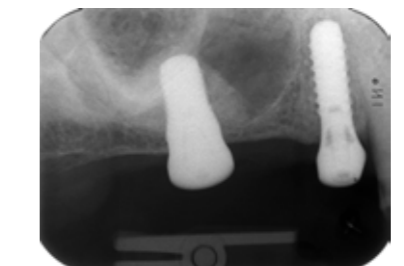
X-ray verification after surgery.
